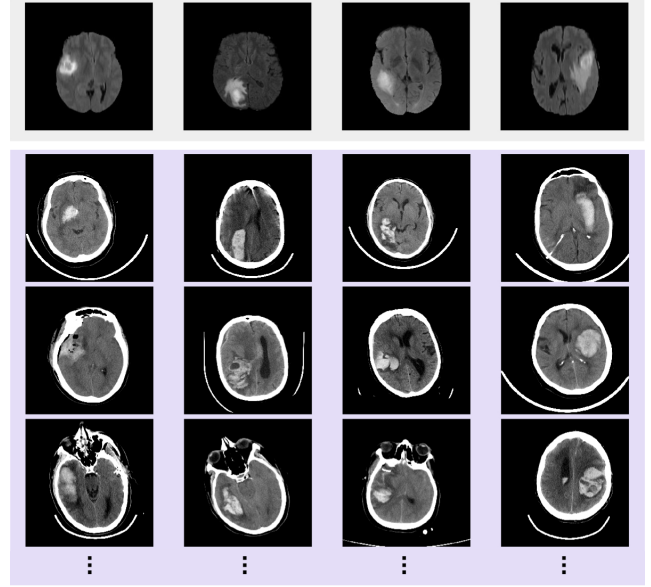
As shown in the figure, each column is an MRI and its corresponding similar CT images, which are matched by our method. We only show the top three CT images with the highest similarity in this figure. The bright circular stripes in CT are CT head holders.
